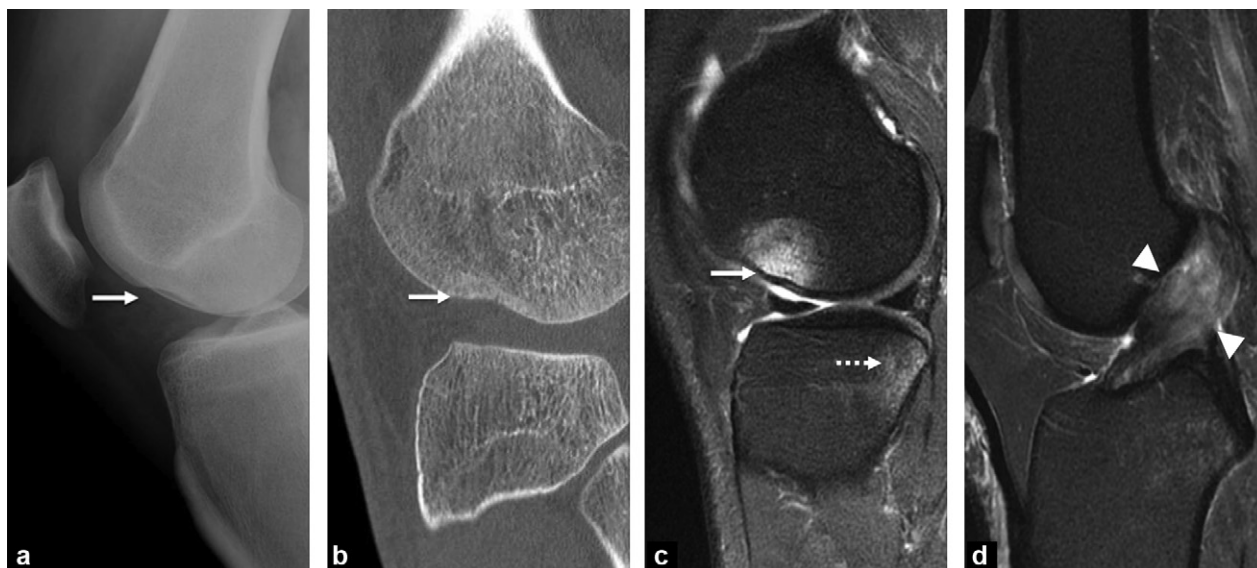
Fracture-impaction of the lateral condyle and the lateral tibial plateau. The anterior translation of the tibia at the time of the trauma induces an impaction of the anterior part of the lateral condyle of the femur on the posterior edge of the lateral tibial plateau. The anterior cruciate ligament (ACL), main stop to this anterior translation, is thereby broken. a: standard X-ray (side): notch of the lateral condyle; b: CT (sagittal). The impaction is clearly visible; c and d: sagittal fat-suppressed proton density MR image signal. Impaction of the femoral condyle (full arrow) and tibial plateau (dotted arrow). Concomitant rupture of the ACL (tip of arrows).
